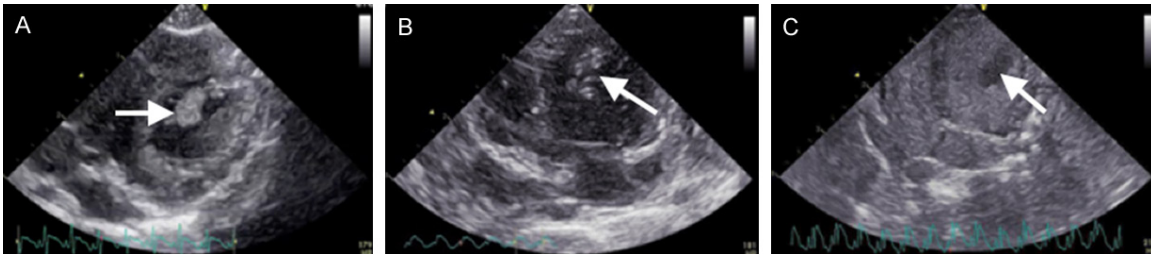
A. Ultrasonography: left ventricular short-axis view shows ovoid left ventricular thrombosis (white arrow). B. Ultrasonography: apical four-chamber view of left ventricular thrombus (white arrow). C. Contrast-enhanced ultrasonography: the left ventricular thrombus in the apical four-chamber view shows a low-anechoic filling defect; the high echo of the contrast microbubbles clearly outlines the thrombus (white arrow).
